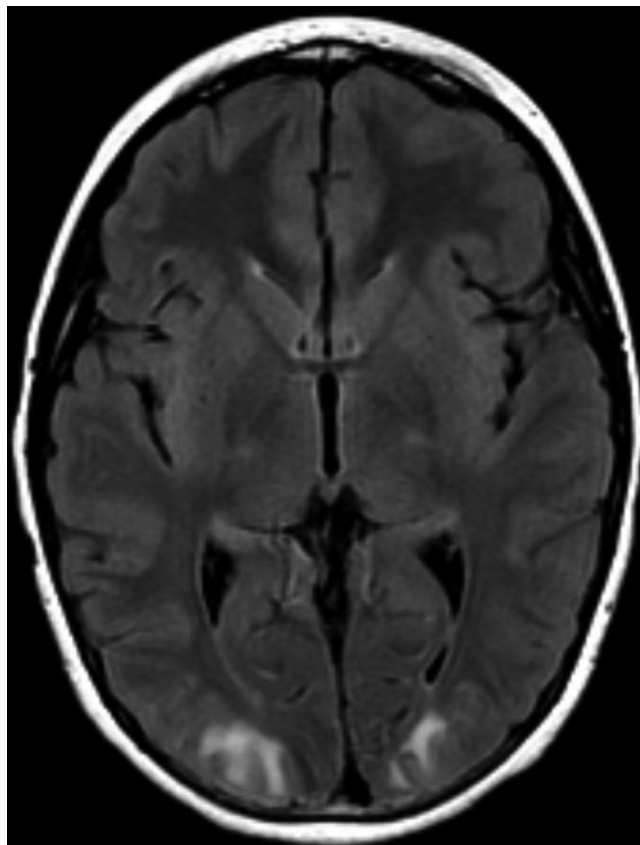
Brain MRI from stem cell transplant recipient with posterior reversible encephalopathy syndrome (PRES). Axial FLAIR image with bilateral symmetric abnormal signal in the occipital subcortical white matter and cortex demonstrating characteristic changes for PRES (Courtesy of Dr. Marcia K Kukreja, MD, Department of Radiology and Medical Imaging, Cincinnati Children’s Hospital Medical Center, Cincinnati OH)
